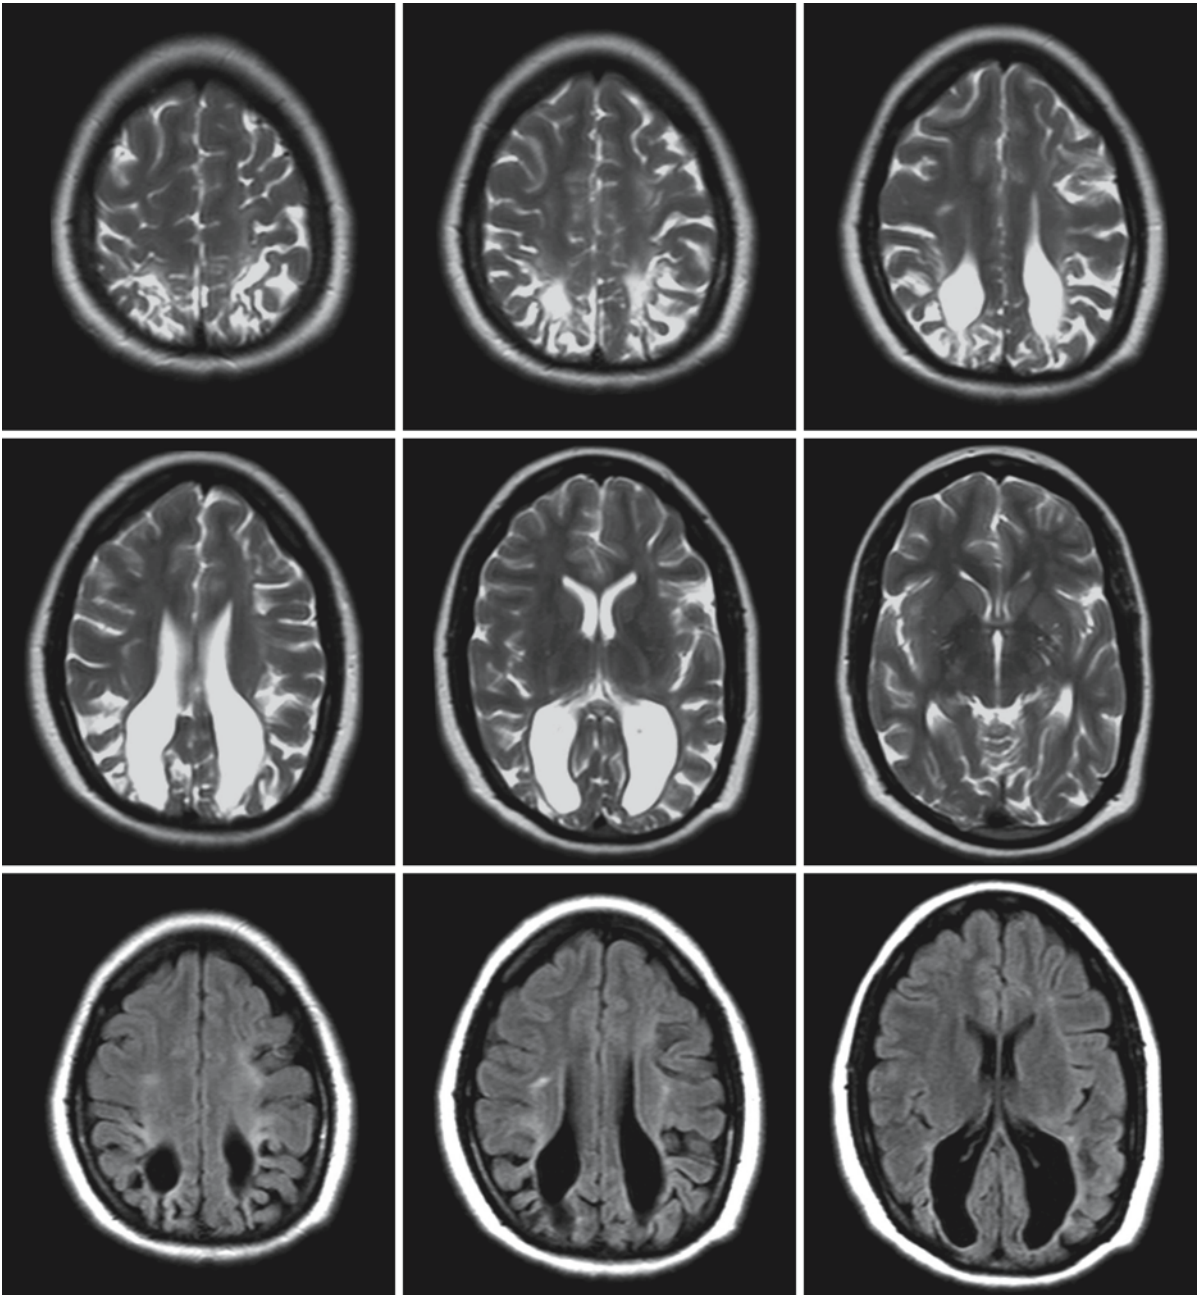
Images of a 32-year-old mentally retarded and visually handicapped man with a history of perinatal asphyxia. It is unclear whether he also suffered from hypoglycemia. The T₂-weighted (*first and second rows*) and FLAIR (*third row*) images show severe white matter loss and gliosis in the parieto-occipital area and crowding of the occipital gyri (ulegyria)
